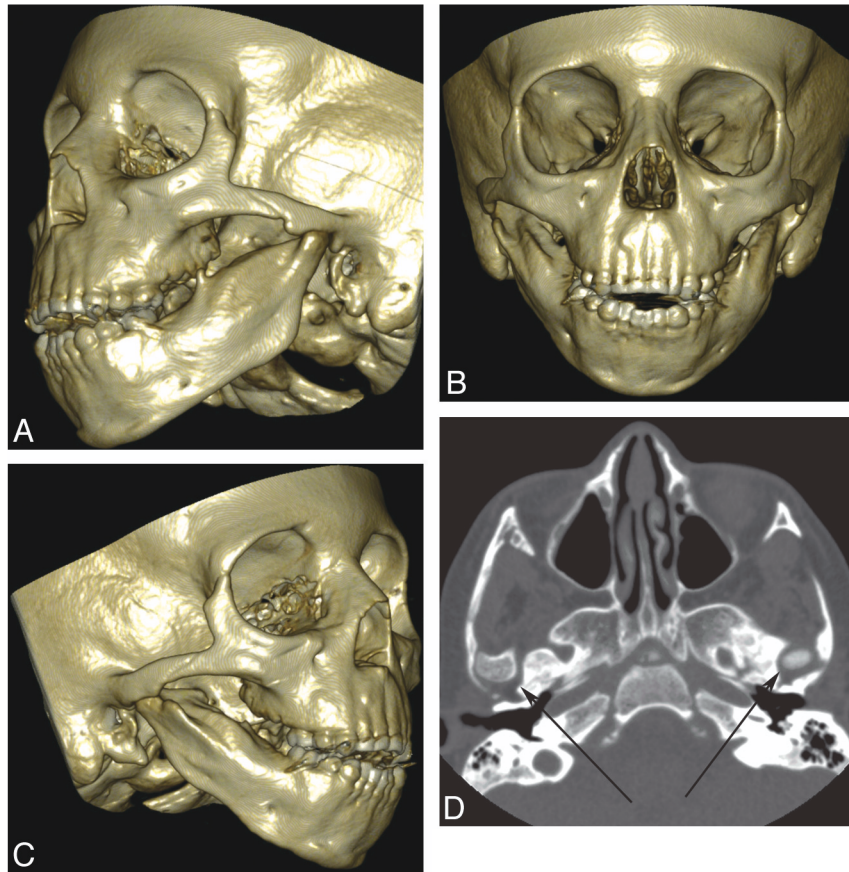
A 5-year-old boy with ACS. *A–C*, 3D bony reconstructions show an absent condylar processes, asymmetric micrognathia, and hypoplastic condyles. *D*, Axial CT scan shows bilateral abnormal TMJs (arrows) with dysplastic condylar processes.
